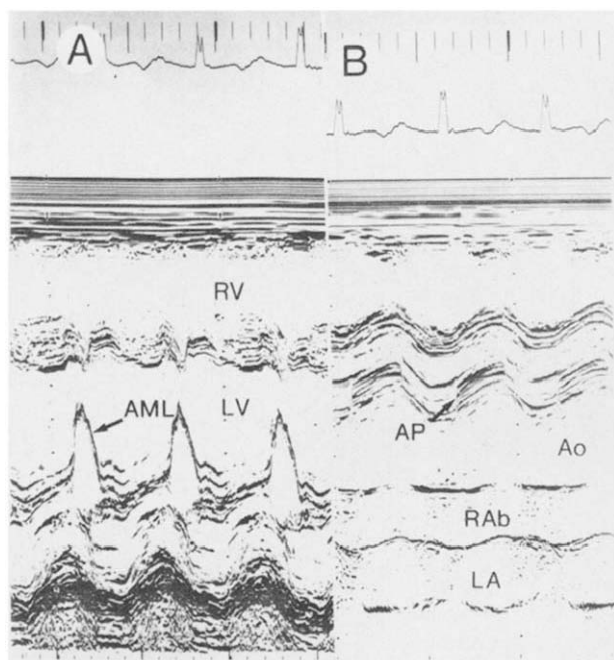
Case 1. M-mode echocardiogram. A, Dilated, hypercontractile left ventricle (LV) and the anterior mitral leaflet (AML) with high frequency diastolic fluttering characteristic of aortic regurgitation. B, Normal-appearing aortic prosthesis (AP) and the valve ring abscess (RAb) that encroaches on the left atrium (LA). Other abbreviations as in Figure 1.
